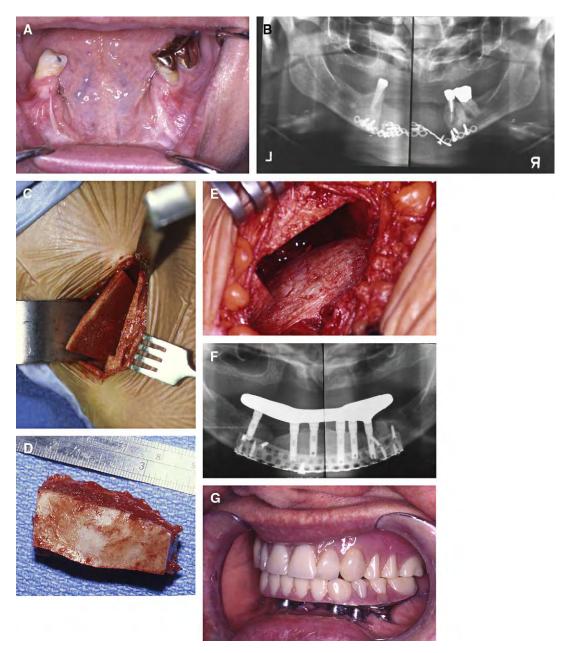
(A) Preoperative clinical appearance of a patient with a 5-cm anterior segmental defect secondary to tumor resection. (B) Preoperative panoramic radiograph shows failure of attempted internal fixation without bone graft. (C) Anterior Iliac crest harvest site shows corticocancellous block graft osteotomized and pedicled to the external oblique muscle. (D) 5×5 cm corticocancellous block graft harvested. (E) Donor site defect created after corticocancellous block harvest. (F) Postoperative panoramic radiograph shows corticocancellous bone graft with titanium mesh crib reconstructed with endosseous dental implants after a 6-month period of graft consolidation. (G) Postoperative view of a patient after final prosthetic reconstruction is completed.
